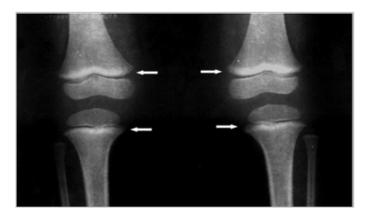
Long Bone Radiograph of Knees – "lead lines" in three-year old girl with BLL of 0.6 μg/dL. Notice the increased density on the metaphysis growth plate of the knee, especially in the femur (Photo courtesy of Dr. Celsa López, Clinical Epidemiologic Research Unit, IMSS, Torreón, México).
